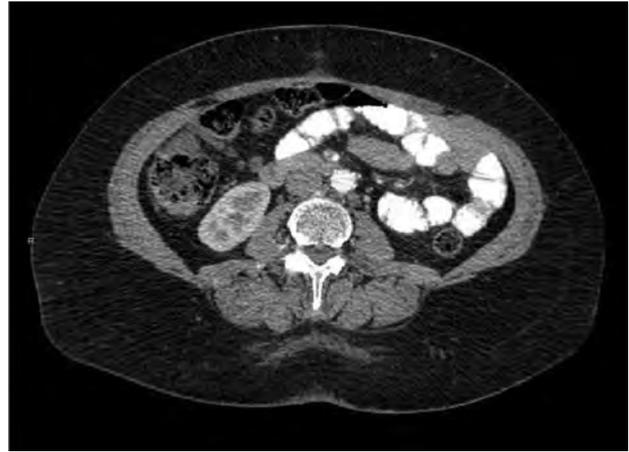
A follow-up computed tomography scan of the abdomen and true pelvis demonstrating reduced multiple tumorous lesions measuring 1.2–1.4 cm. No abnormalities in the true pelvis are seen. The uterus is 6.2×3.5 cm in size with a smooth and clear contour without evidence of infiltration.
